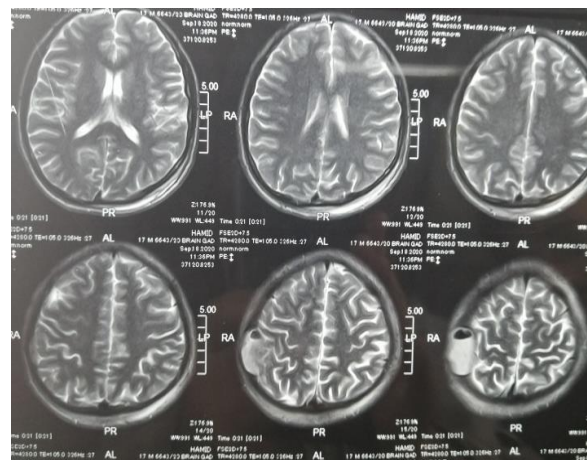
MRI brain (Axial T2WI), showing a hyperintense lesion with area of hypointensity within right bone.
